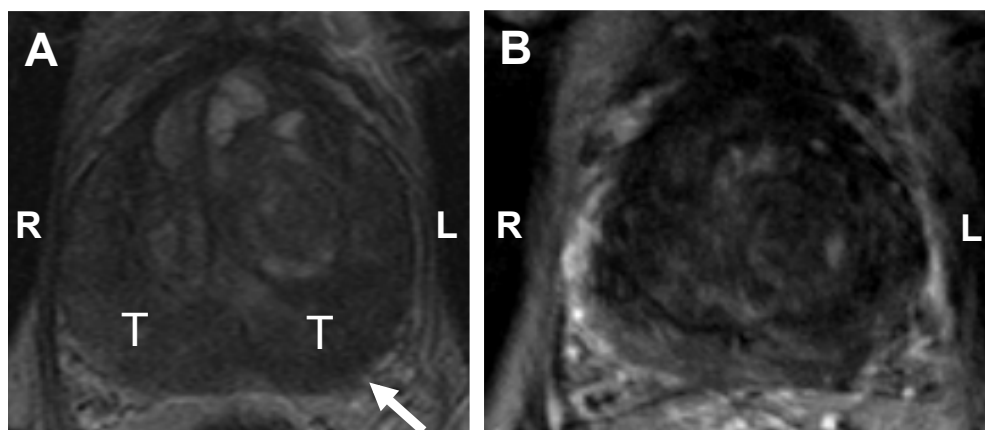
(A) Axial T2-weighted spin-echo MR image at 1.5 T before therapy from the midgland of the prostate of a 77-year-old man with a PSA level of 30 ng/mL and biopsy-proven Gleason 3 + 5 = 8 prostate cancer using a pelvic phased-array coil (TR/TE: 4400/132 milliseconds). A large area of low signal intensity indicative of tumor (T) covering the whole peripheral zone of the prostate from apex to base was observed. Signs of capsular bulging (arrow) and seminal vesicle invasion (not shown) are present. (B) Two and a half years after radiation therapy, the axial T2-weighted fast spin-echo image (TR/TE: 3100/135 milliseconds) at 3 T with combined body and spine matrix coils reveals a homogeneously low signal in the entire prostate, indicative of postradiation therapy effects. L, left; R, right; T, tumor.
